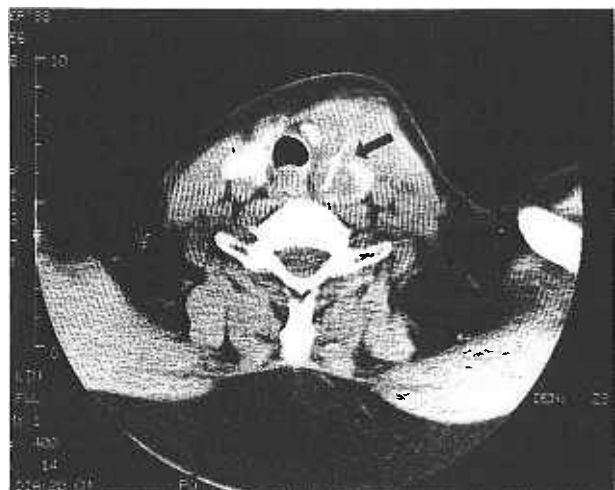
Axial CT scan of the neck showing a fish bone embedded in the left thyroid gland surrounded by soft tissue swelling suggestive of an intralobal abscess.
